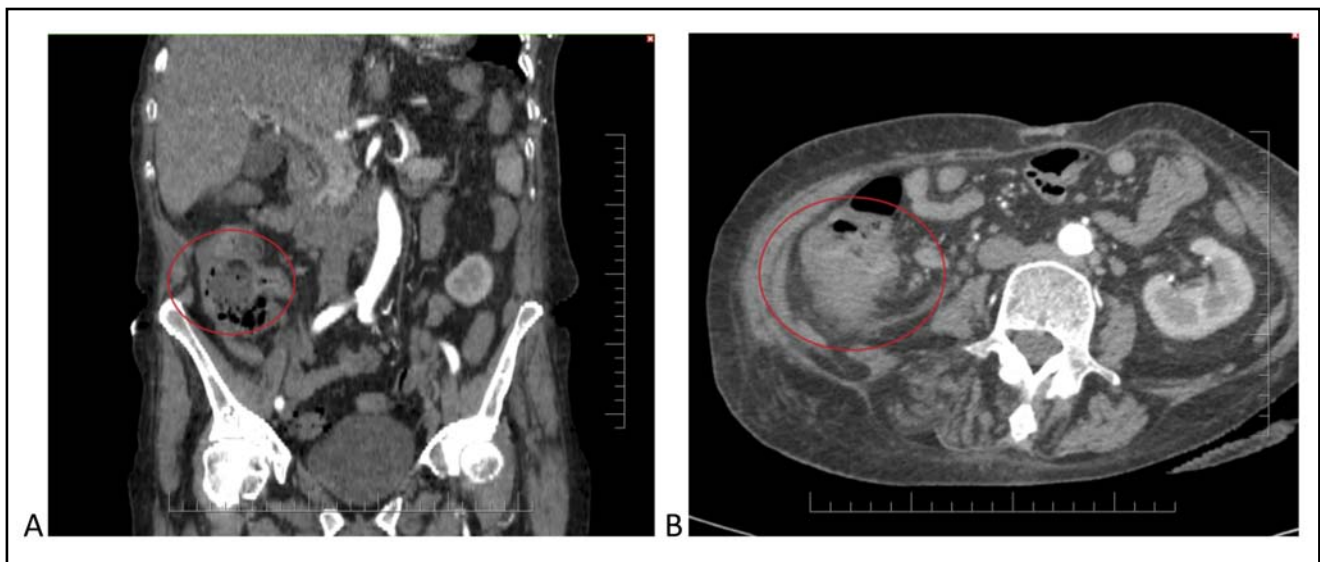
Contrast-enhanced abdominal CT scan showing a tumour of the ascending colon (red circle): A) coronal projection; B) axial projection
